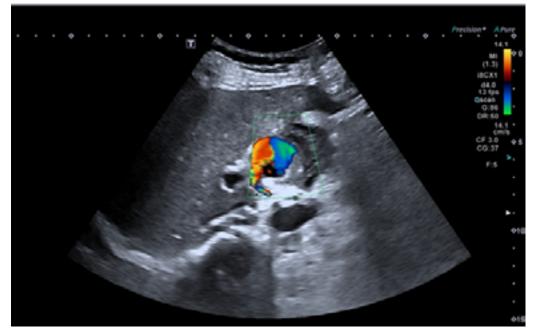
Ultrasound image of right hypochondrium with color doppler flow in the anechoic cystic lesion at porta.
